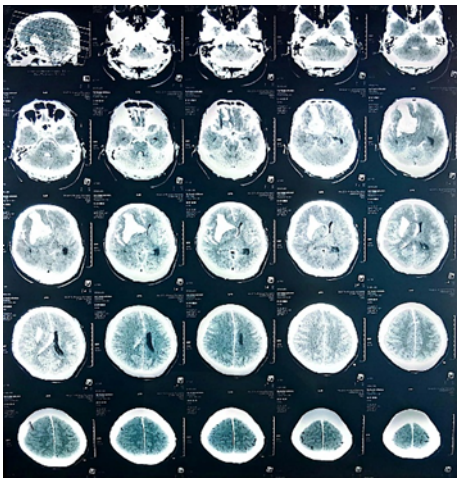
CT Plain Head (showed ICH in the right frontal lobe, IVH, SAH, and Increased ICP)
